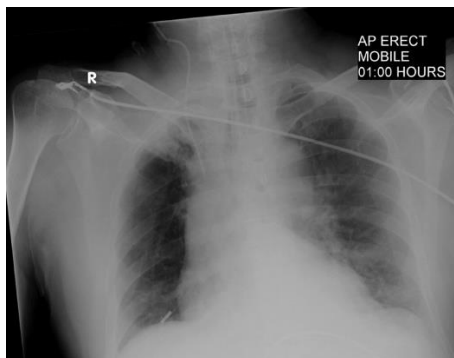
A chest radiograph. The metallic density seen in the lower right lung field is a naso-gastric tube in the right lower lobe bronchus.
